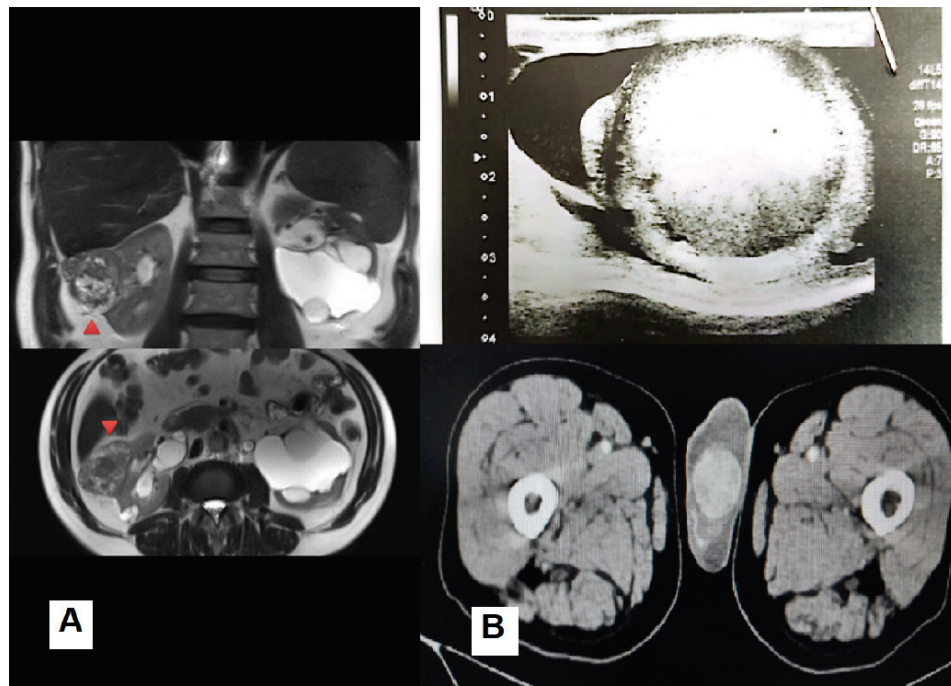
A. MRI of the right kidney mass, B. US and CT images of testicular mass 663x475mm (47x47 DPI)
